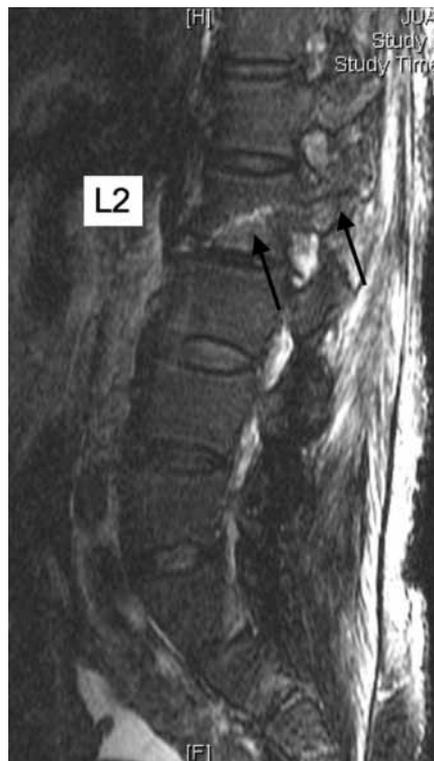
MRI T2-weighted image (paramedian sagittal view). The black arrows indicate the fracture line through the L2 vertebral body and pedicle.
